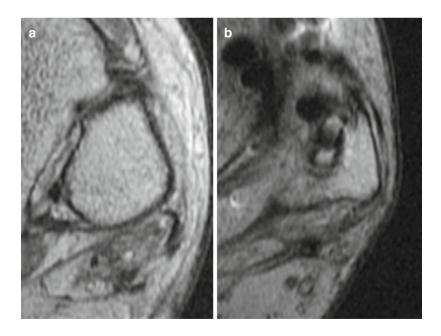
MRI shows complete ruptures of both peroneal tendons
